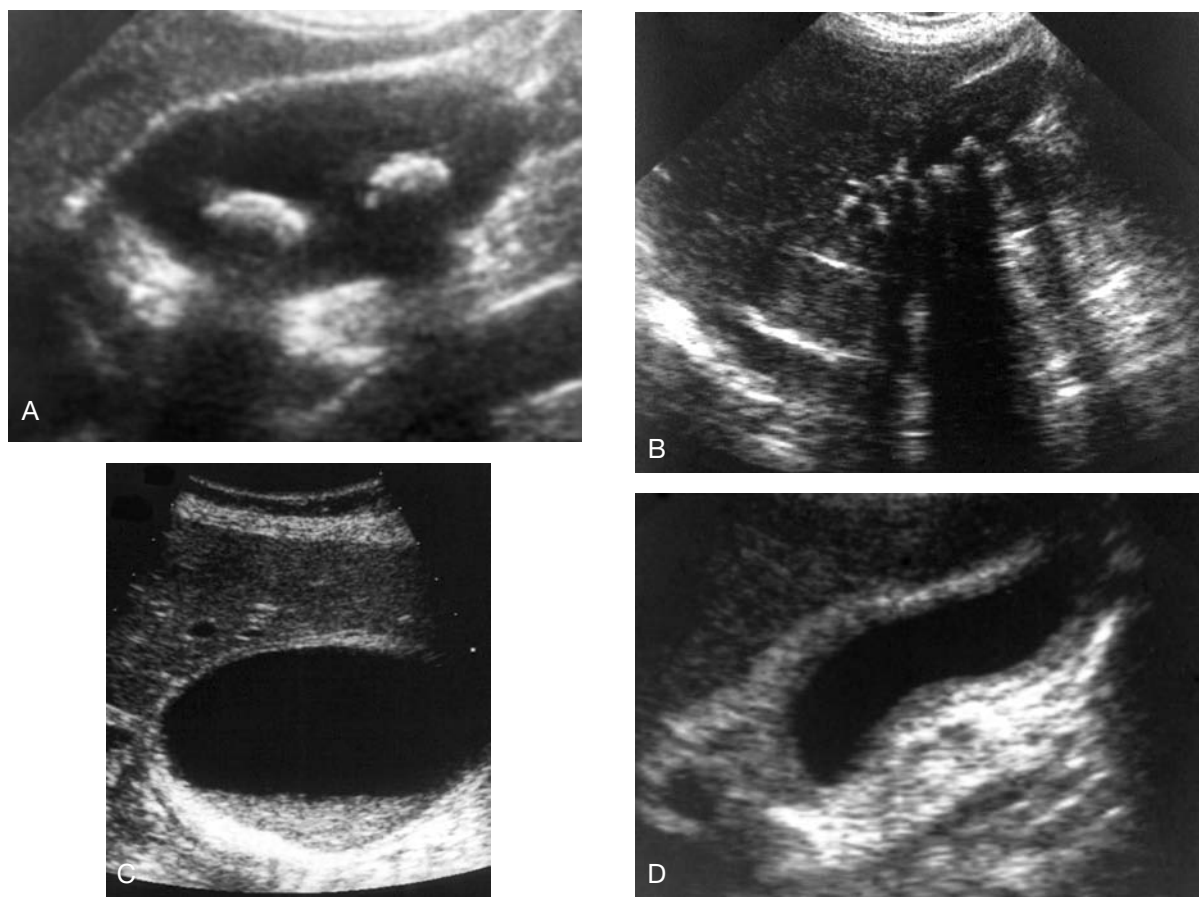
Gallbladder ultrasonography. *A*, Shadowing, mobile, echodense gallstones in a normal lumen. *B*, Tightly packed and less discrete stones in a contracted gallbladder. *C*, Gallbladder sludge composed of cholesterol crystals and mucus and seen during prolonged gallbladder stasis, as with total parenteral nutrition or during pregnancy. *D*, Thick, edematous gallbladder mucosa sometimes seen with acute cholecystitis, portal hypertension, ascites, or hypoalbuminemia.
